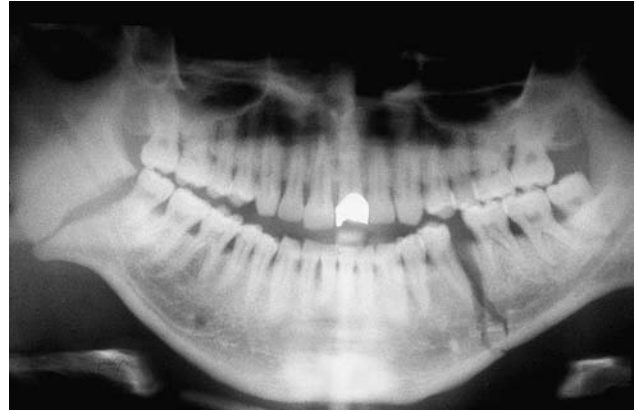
Panoramic radiograph with a left body fracture (comminuted) and a right angle fracture.
